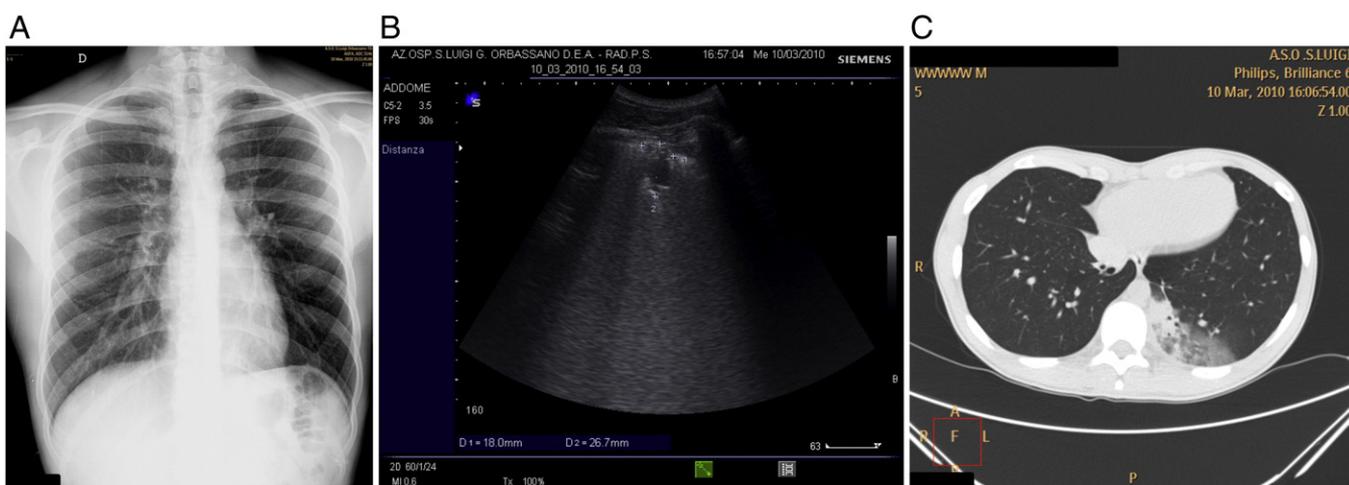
A, Upright CXR study of a 28-year-old man admitted to the hospital because of severe left dorsal pleuritic pain and cough. B, Corresponding sonogram of the painful dorsal chest area showing irregular pleural line, coalescent B-lines (B+ pattern), and subpleural irregular shape consolidation. C, Corresponding sCT scan. One basal dorsal soft consolidated area of the lung is visible. The final diagnosis was radio-occult pneumonia.
